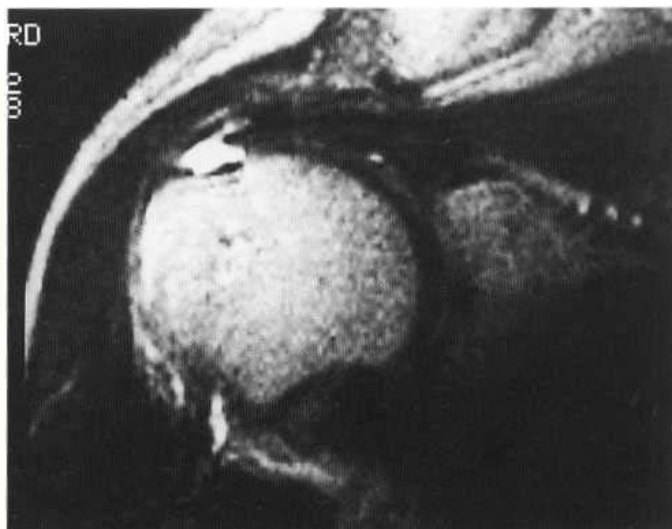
Total rotator cuff tear with retraction. Axial CT of the shoulder demonstrates an anterior labral tear.
